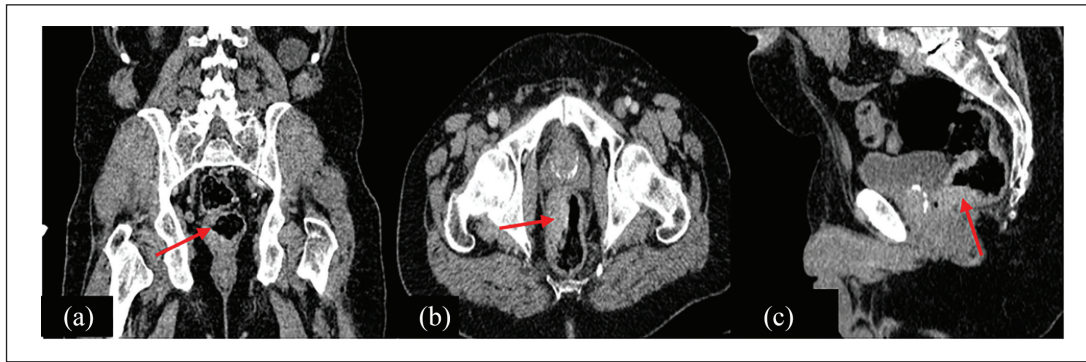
A contrast-enhanced computed tomography (CT) scan in a 63-year-old man with protruding anal lesion diagnosed with melanoma of the rectum shows on coronal (a) axial (b) and sagittal (c) images a heterogeneous, irregular endophytic rectal tumor without extension into peri rectal fat (red arrow).
